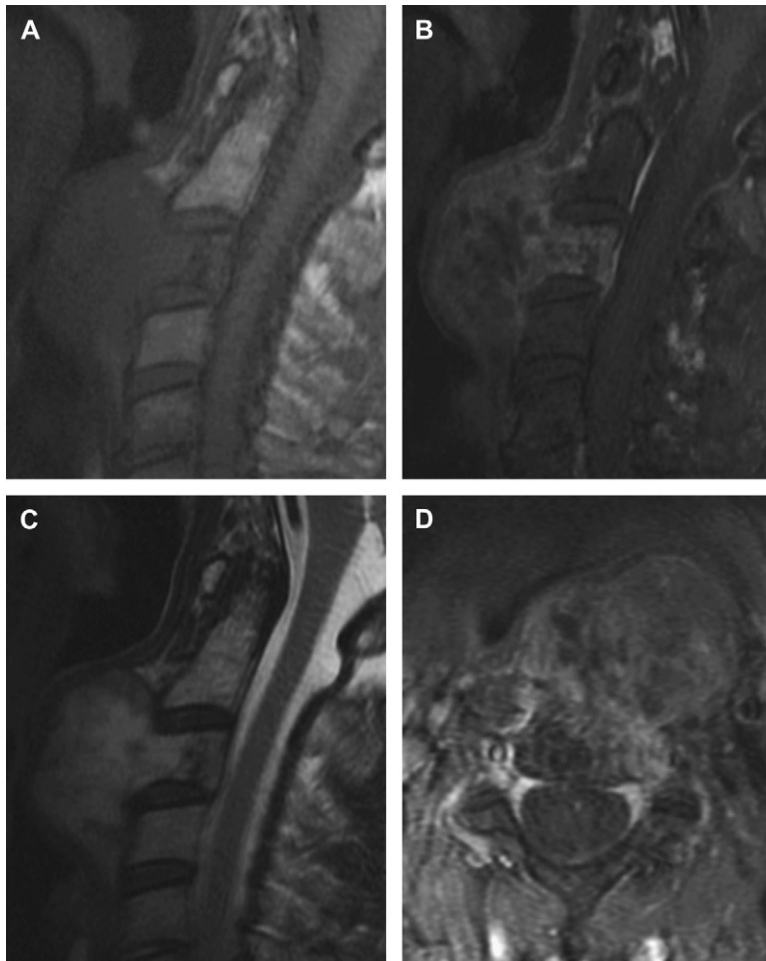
MRI demonstrates extensive retropharyngeal extension of a C3 chordoma. Sagittal T1 (A), sagittal T1 with gadolinium (B), sagittal T1 (C), and axial T2 (D) images are shown.
